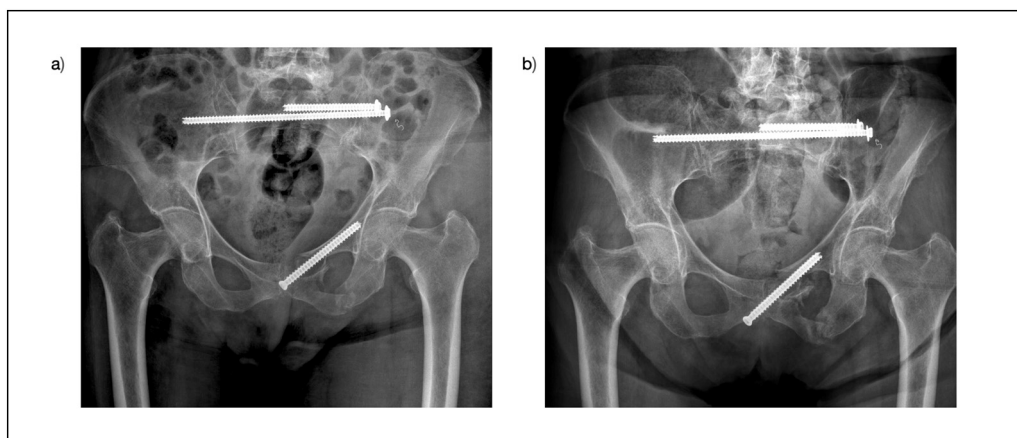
a) X-ray day after surgery, b) X-ray at 12 months follow-up.
